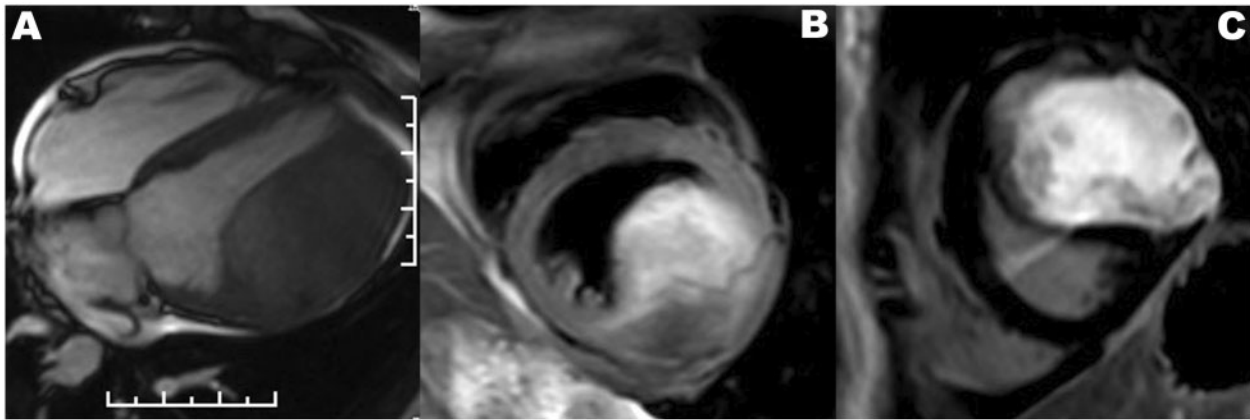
Cardiac magnetic resonance imaging revealed an 82 mm × 51 mm thickness of the left ventricular wall with low signals on T1-weighted imaging (A), uneven high signals on T2-weighted imaging (B), and abundant blood supply in the cardiac mass with gradual late gadolinium enhancement (C).
